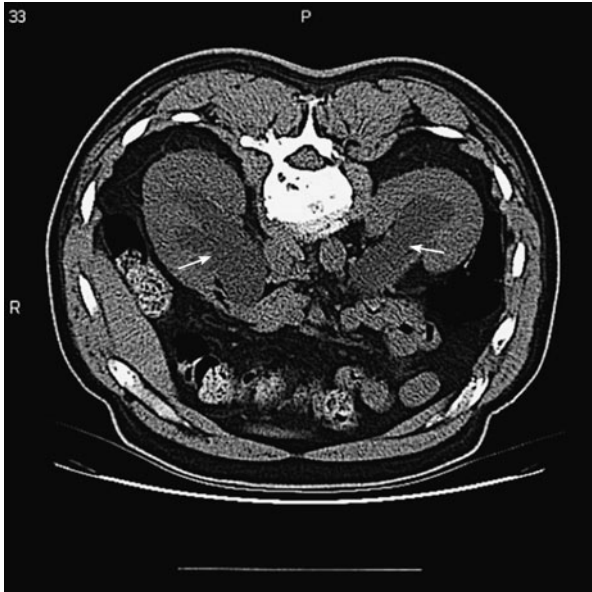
Obstructive uropathy. CT scan demonstrates dilation of both renal collecting systems (arrows) caused by obstruction from bladder cancer. (Courtesy of Mark A. Perazella.)
